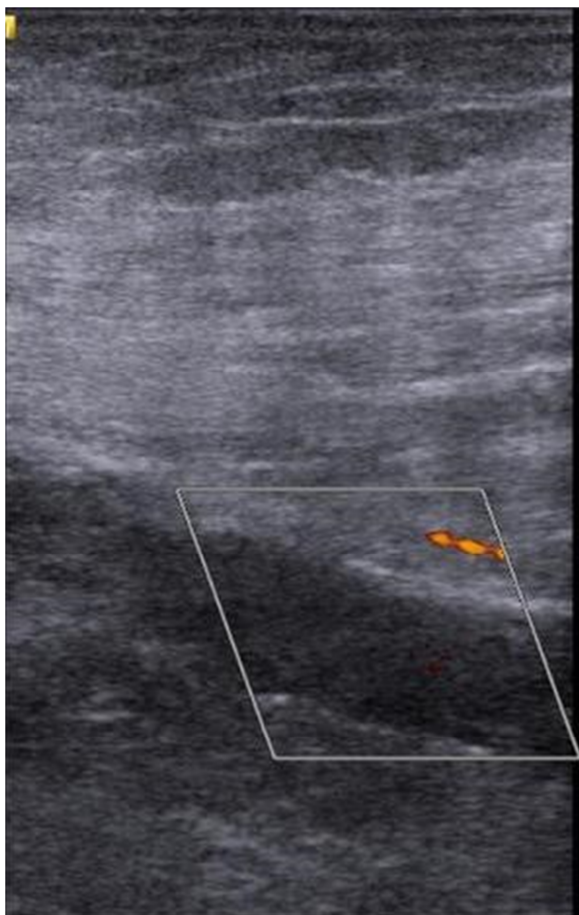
Arterial doppler ultrasound of lower left limb showing an echogenic mass compatible with thrombus causing complete obstruction of distal femoral artery.
